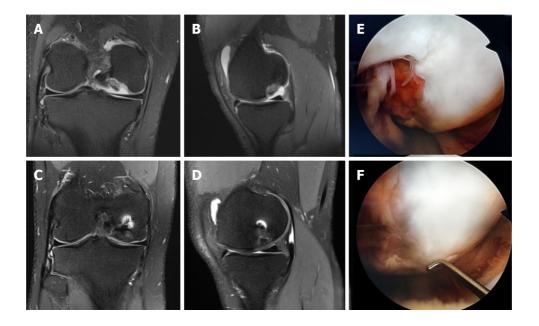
Magnetic resonance images and intraoperative images of a patient treated with the Autologous Tendon Transplantation technique, A. B: Coronal and Sacittal T2 section magnetic resonance images (MRI) of a grade 4 osteochondral lesion involving articular surface of medial femoral condyle (3.4 cm² size and 0.5 cm depth) in 24-year old male; C, D: 1-year follow-up coronal and sagittal T2 section MRI showing complete filling of the defect and establishment of smooth articular surface; E, F: Second look arthroscopy view at 1-year follow-up of grade 4 osteochondral lesion of medial femoral condyle showing filling of the defect with a well-integrated, smooth surfaced and stable regenerated cartilage.
